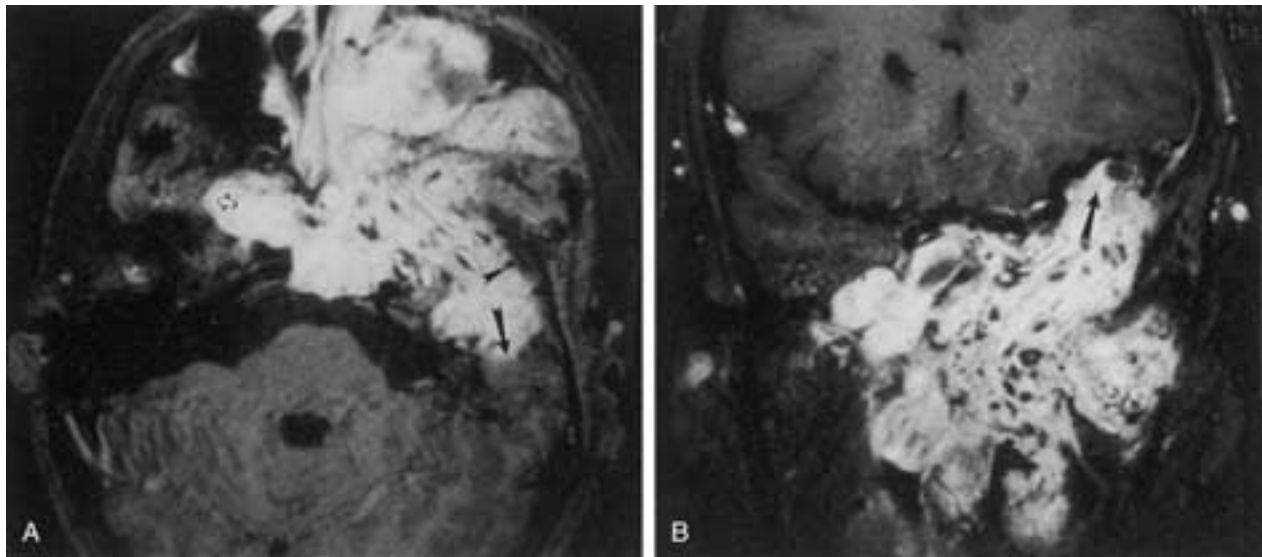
Juvenile angiofibroma. A, Axial postgadolinium T1-weighted image with fat suppression. This extensive tumor extends across the midline into the opposite infratemporal fossa (*open arrow*). There is extensive tumor (*black arrow*) extending intracranially. Flow voids (*arrowheads*) are seen within the tumor. B, Coronal postgadolinium T1-weighted image with fat suppression shows extensive intracranial tumor (*black arrow*) protruding superiorly. The lesion parasitizes branches of the middle cerebral artery.
